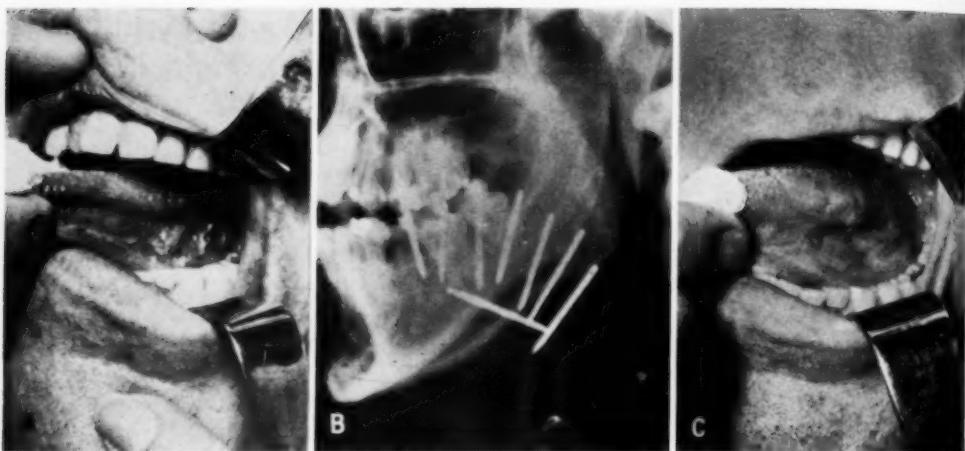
Flat squamous-cell carcinoma, Grade 2, involving the posterior and lateral tongue with extension to the lateral floor of the mouth. B. X-ray demonstration of the radium needle pattern. C. Primary healing two months after therapy. Note that the teeth have not been disturbed.
